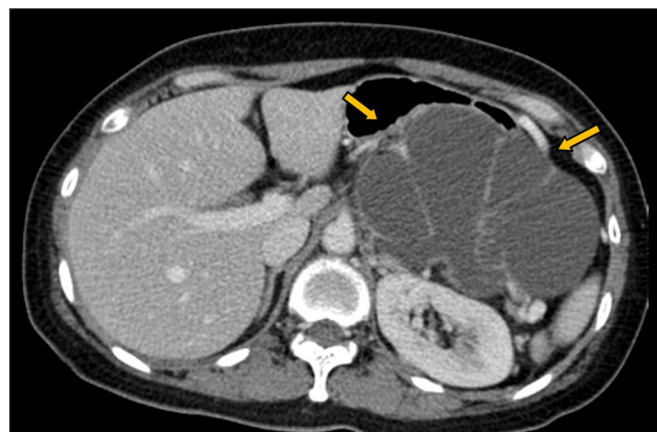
Preoperative CT images of a patient with multilobular MCN.
